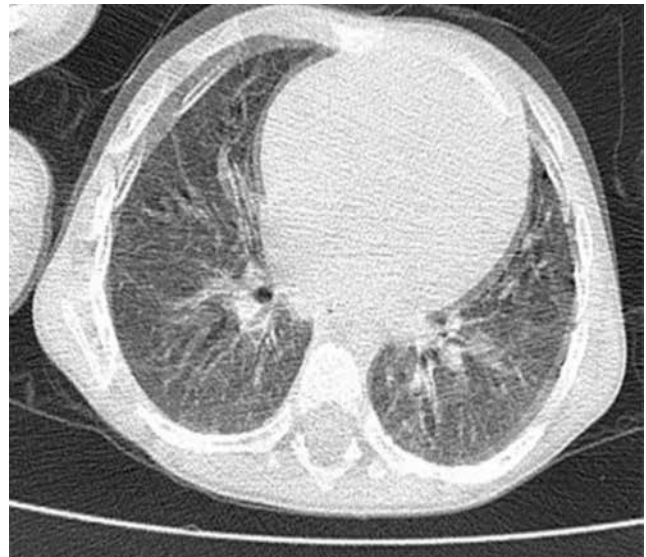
Microcystic formations visible on pulmonary computed tomography
